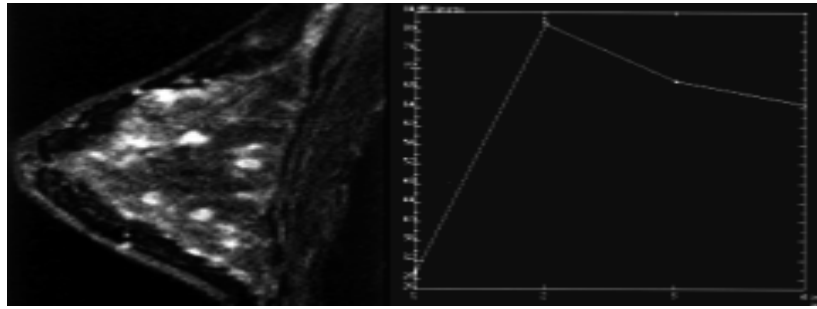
A. Sagittal fat-suppressed contrast-enhanced 3D fast SPGR MR image (9.2/2.1) of the right breast showing multifocal areas of enhancement, suggestive of carcinoma. B. Followed by a strong washout
